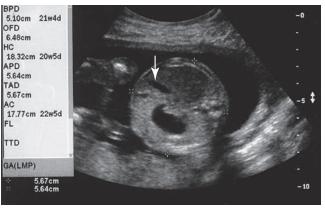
Cross-sectional sonogram of the fetal abdomen.
